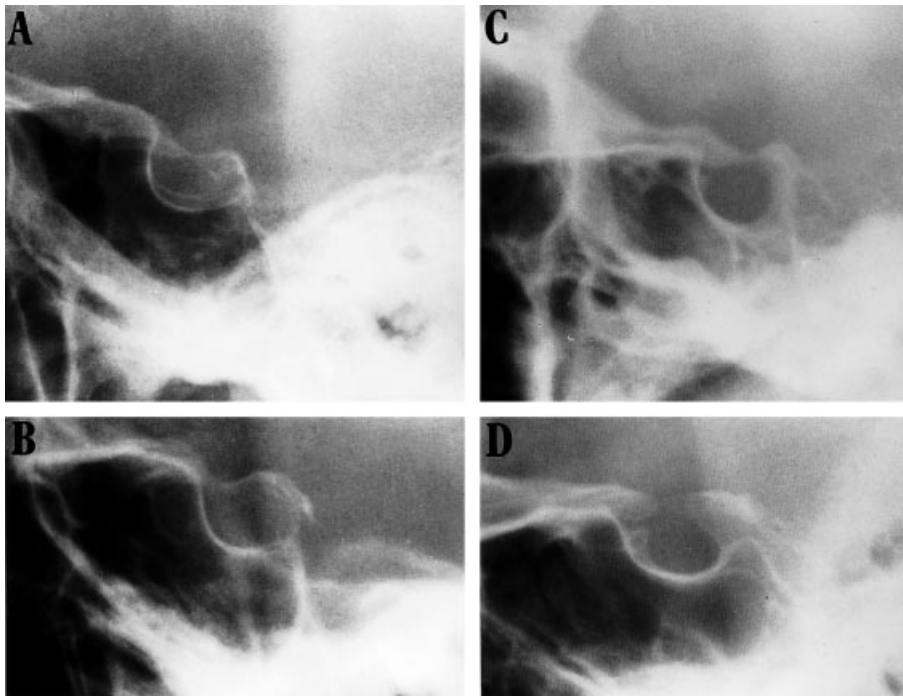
(A–D) Radiographs of the sella turcica region showing four different sella turcica bridges, type A, with manifest, ribbon-like fusion.
